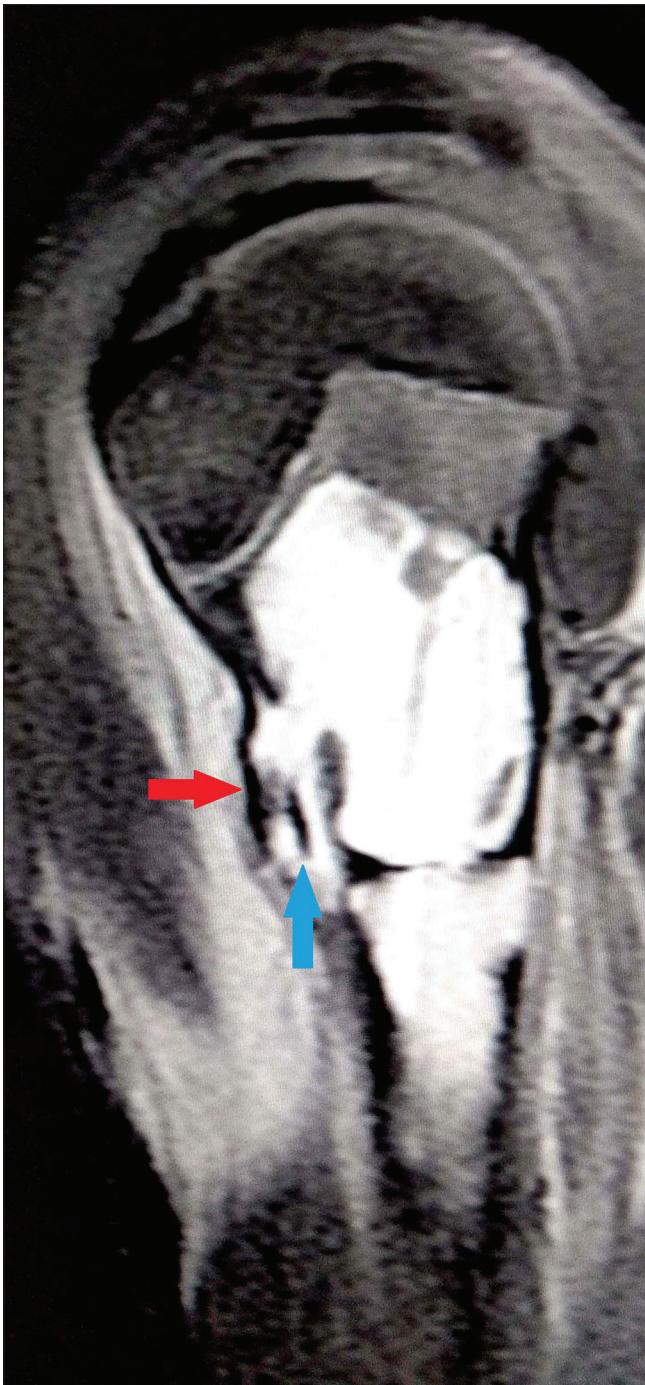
Coronal MERGE (gradient) MR image of the shoulder joint demonstrating radiological signs in a unicameral bony cyst involving the proximal humerus in a 12-year-old boy. Note the meta-diaphyseal location of the cyst with no extension across the epiphyseal plate. Linear hypointense focus is seen in the dependent position indicating "Fallen fragment sign" (red arrow). Endosteal scalloping (pink arrow) and internal septation (green arrow) is being demonstrated. Note the periosteal elevation with collection demonstrating blood-fluid level (blue arrow)
